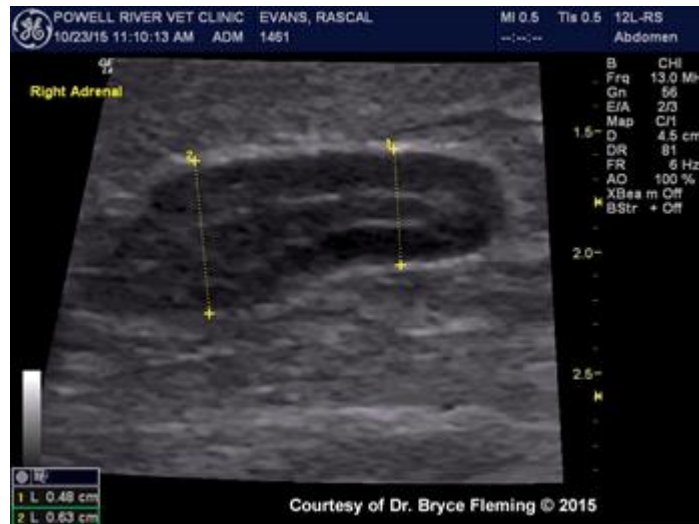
Normal adrenal gland (ultrasound)
